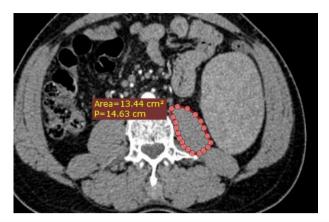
CT image: Skeletal muscle area at the level of L3
